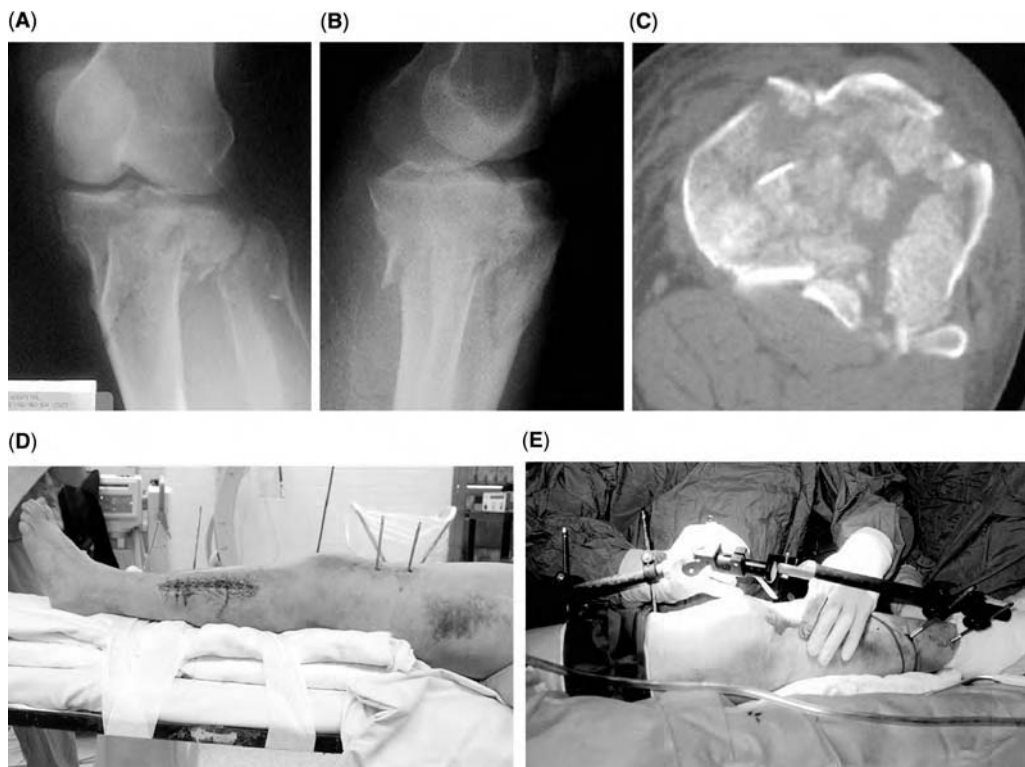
(A and B) High-energy bicondylar Schatzker VI (41 C3), tibial plateau fracture with compartment syndrome. (C) Computed tomography scan of complex plateau fracture. (D) Stage II—definitive treatment two weeks after compartment release and temporizing external fixation. Half-pins are prepped into the field and the fixator is removed and sterilized to be placed back on for intraoperative distraction. (E) Definitive articular reduction using the bridging fixator as a distraction device.
